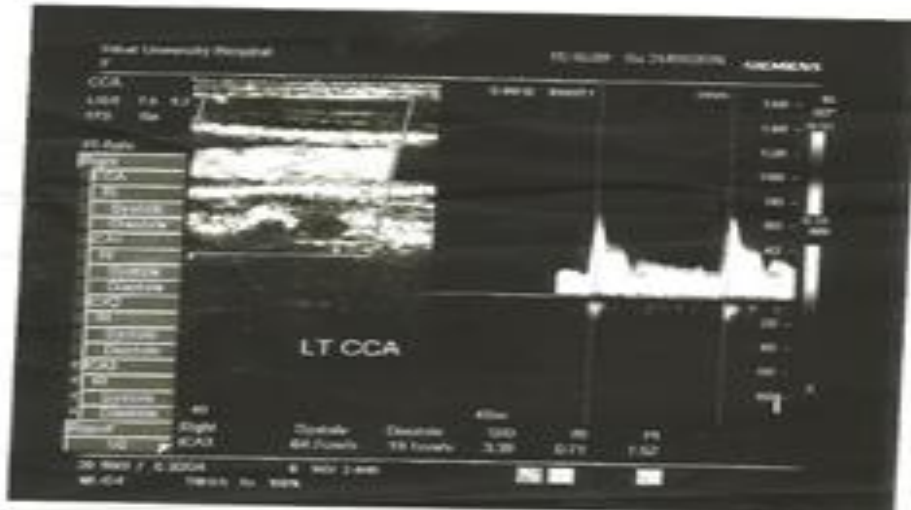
Lt ICA-female- 68 years diabetic patient with normal Doppler parameters.
